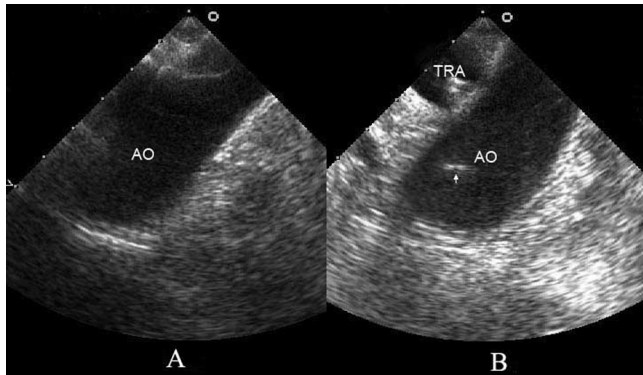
Transesophageal echocardiographic images of upper esophageal aortic arch long axis with and without the saline-filled endotracheal balloon. (A) Without the endotracheal balloon, approximately two thirds of the posterior wall of the aortic arch was not seen. (B) With the presence of a saline-filled endotracheal balloon, the trachea was seen as a round echo-free space, and the proximal aortic arch was visualized anterior to the trachea. The entire posterior wall of the aortic arch was seen clearly in this view. There is a reverberation artifact resulting from the tracheal balloon shaft in the aorta (arrow). AO = aortic arch; TRA = trachea.
